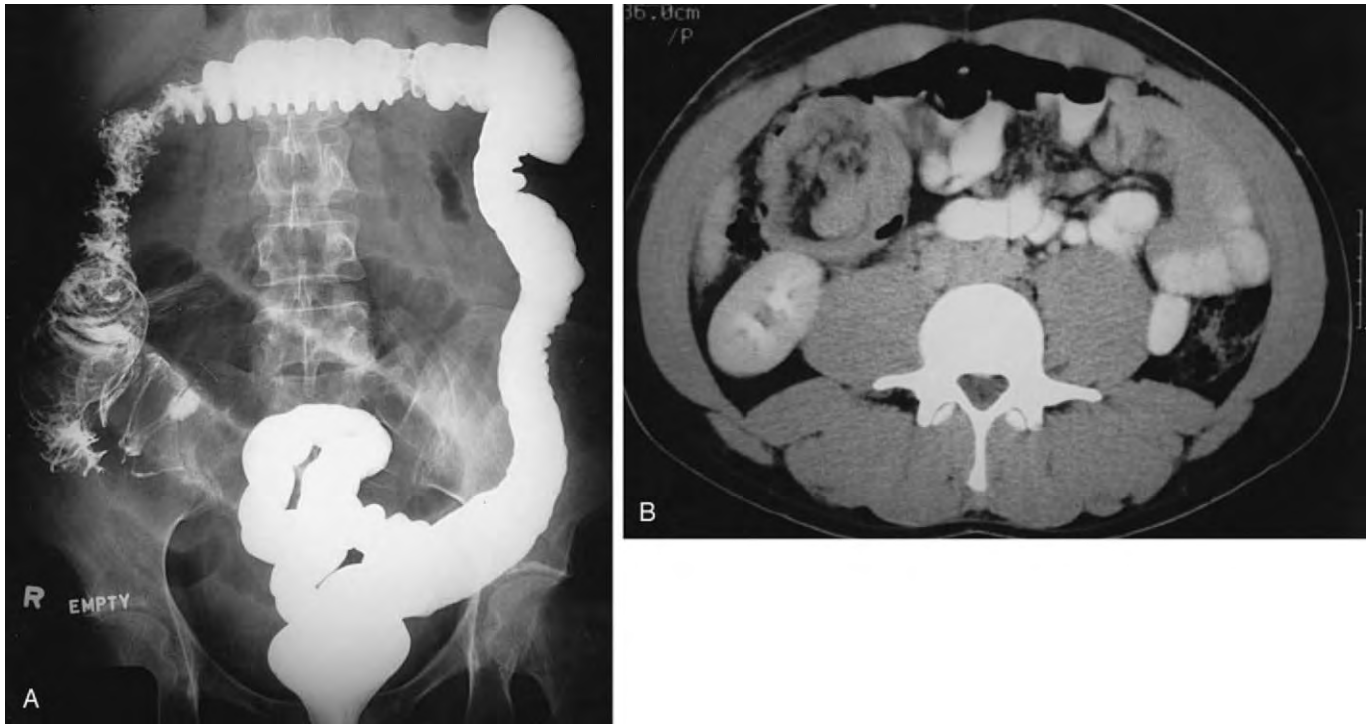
A, Barium enema of ileocolic intussusception demonstrating an invaginating mass into the right colon with the “coiled-spring” appearance of proximal small bowel obstruction. B, CT scan showing ileocolic intussusception, with the typical “bull’s eye” appearance of bowel within bowel in the right abdomen.
